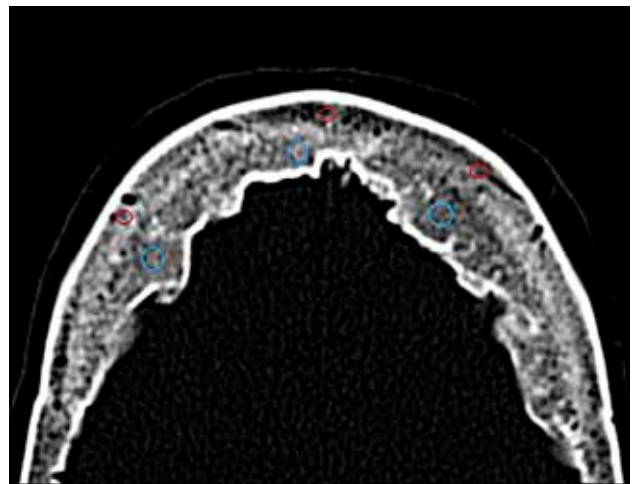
Cranial CT scan, axial plane. Density of the frontal bone. Red circle: Density was measured in the non-HFI part of the frontal bone. Blue circle: Density was measured in the HFI part of the frontal bone.
